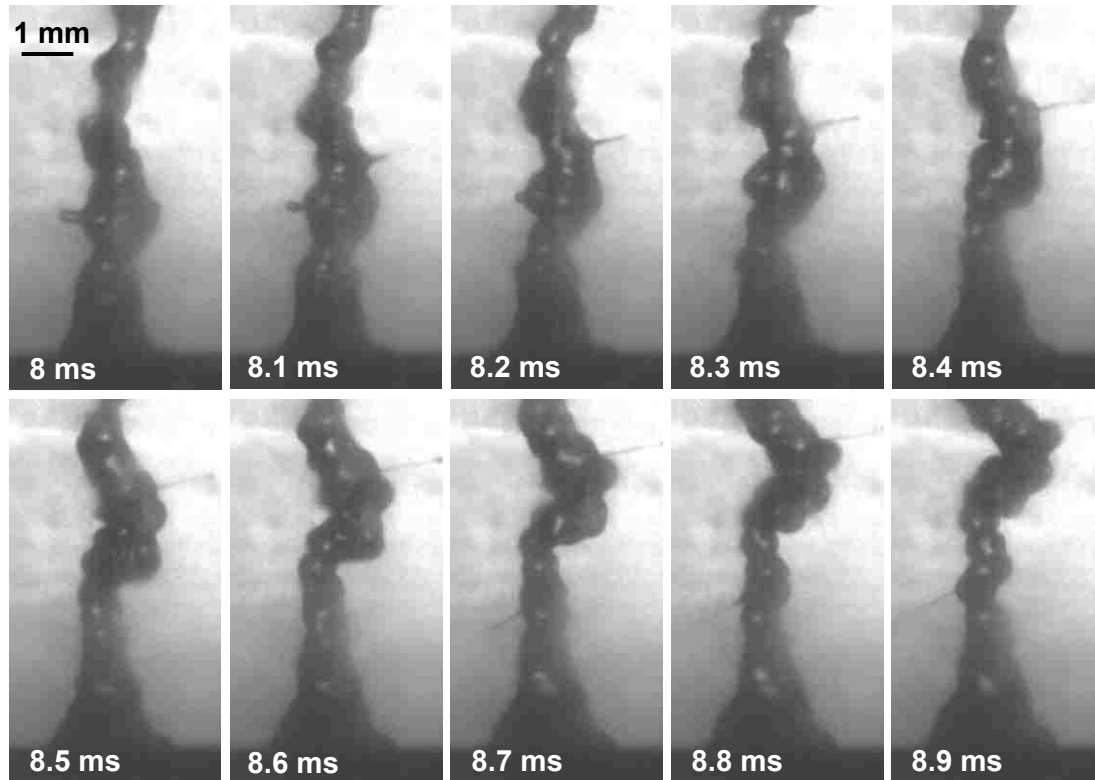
Frames taken from the high speed video (10,000 fps) of olive oil when exposed to 550 W/cm^2 ($p_+ = 5.5 \text{ MPa}$, $p_- = 4 \text{ MPa}$), the threshold of atomization for olive oil. From the image sequence, we can see a jet being emitted from the drop chain on the right hand side starting at 8.1 ms. The jet velocity is 3.7 m/s. In the frame taken at 8.7 ms, we can see a jet emitted from the left hand side of the drop chain with a velocity of 5.3 m/s. The emission of jets in olive oil looks qualitatively different from the drops emitted from the water drop chain. The total ultrasonic exposure time was 10-ms.
